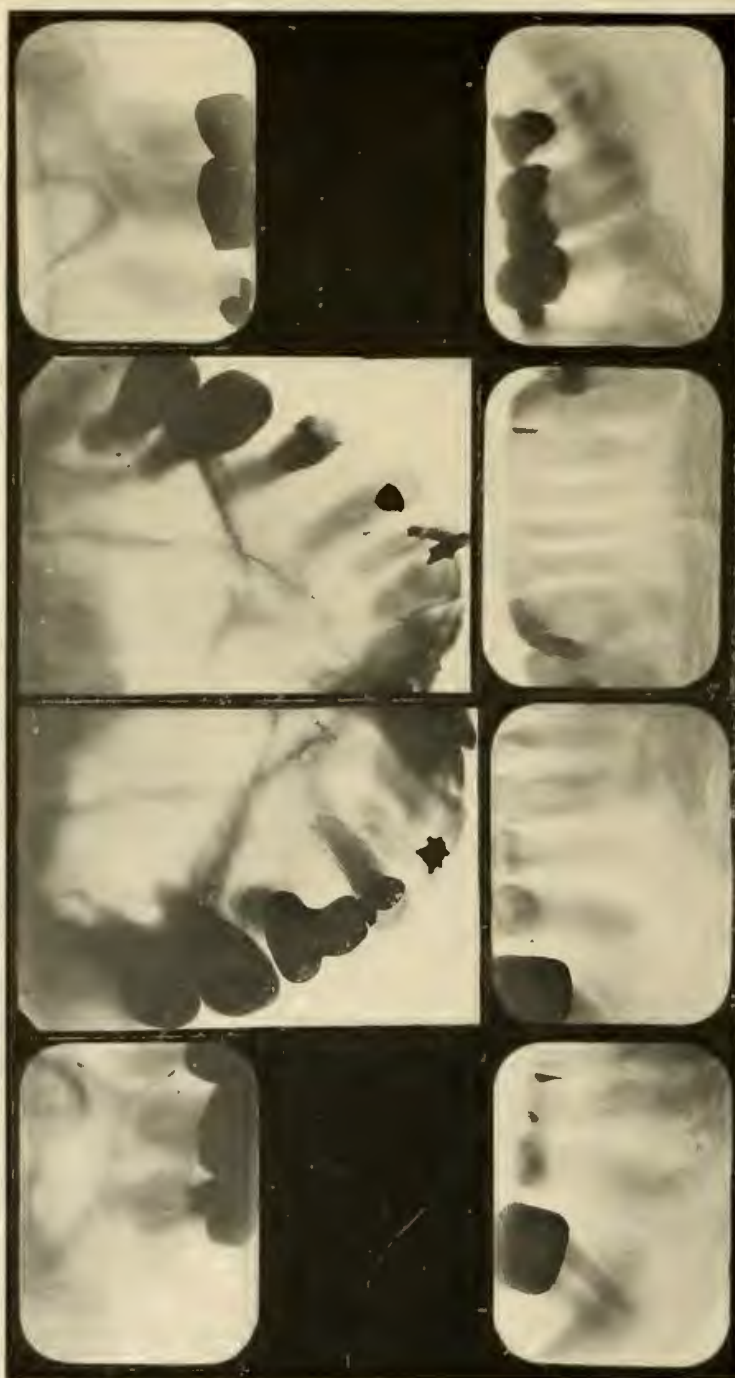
ROENTGENOGRAPHIC RECORD OF THE TEETH OF THE PATIENT SHOWN IN FIGURE 178.
